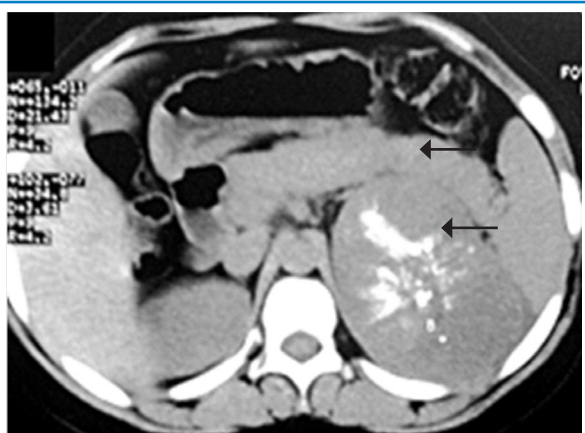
Plain CT scan of abdomen in axial view showing a large mass (arrow) with calcifications pushing the body and tail of pancreas (diamond arrow) anteriorly.
